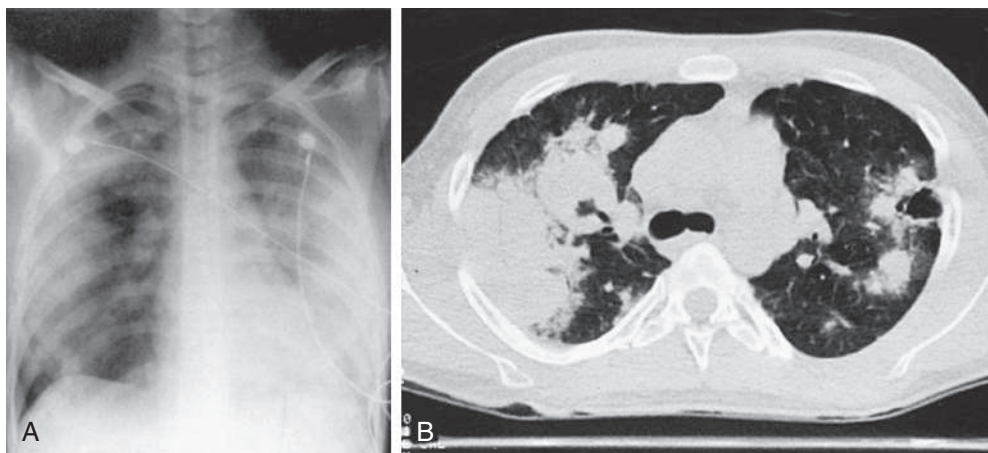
Radiographs of lower respiratory tract disease in granulomatosis with polyangiitis (GPA). A, Chest radiograph of 14-yr-old girl with GPA and pulmonary hemorrhage. Extensive bilateral, fluffy infiltrates are visualized. B, Chest CT scan in 17-yr-old boy with GPA. Air space consolidation, septal thickening, and a single cavitory lesion are present. (A from Cassidy JT, Petty RE. *Granulomatous vasculitis, giant cell arteritis and sarcoidosis*. In *Textbook of Pediatric Rheumatology*, 3rd ed. Philadelphia: Saunders; 1995; B from Kuhn JP, Slovis TL, Haller JO. *Caffey's Pediatric Diagnostic Imaging*, 10th ed. Philadelphia: Mosby; 2004.)
